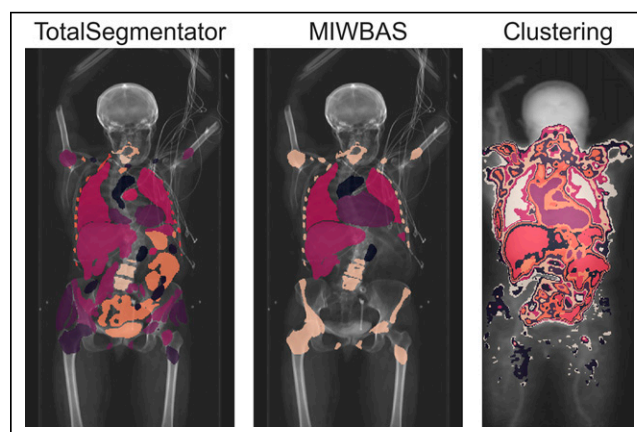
Example of automated tissue segmentation of total-body PET/CT images done with TotalSegmentator (CT-based), MIWBAS (CT-based), and clustering (PET-based). Segmentations at middle coronal slice are visualized with original CT or PET image (sum over coronal slices to flatten them into 2 dimensions) in background for reference. TotalSegmentator and MIWBAS segment their predefined volumes of interest, whereas clustering segments all areas that end user defines as foreground without annotating resulting segments.
